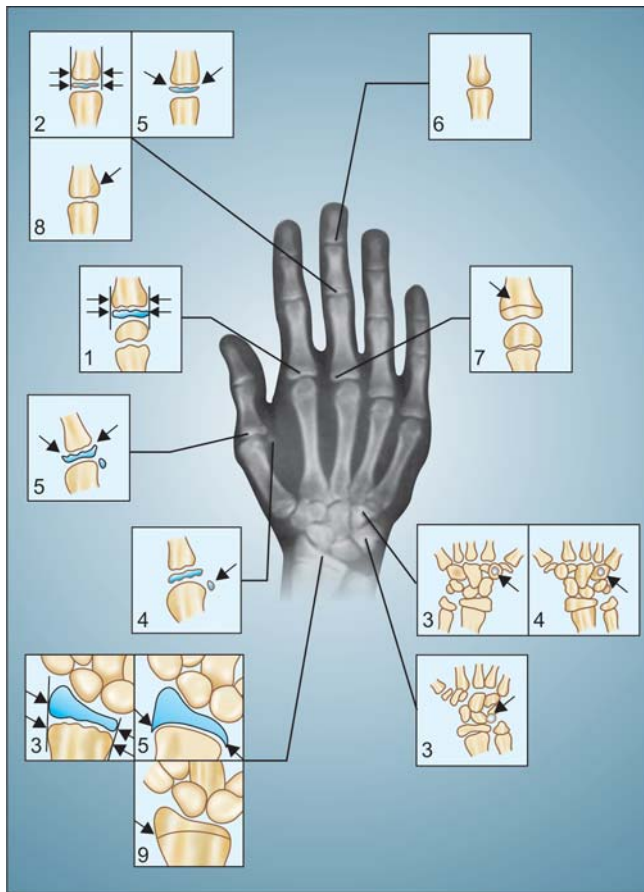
Bjork, Grave and Brown method of assessment of hand wrist X-rays
